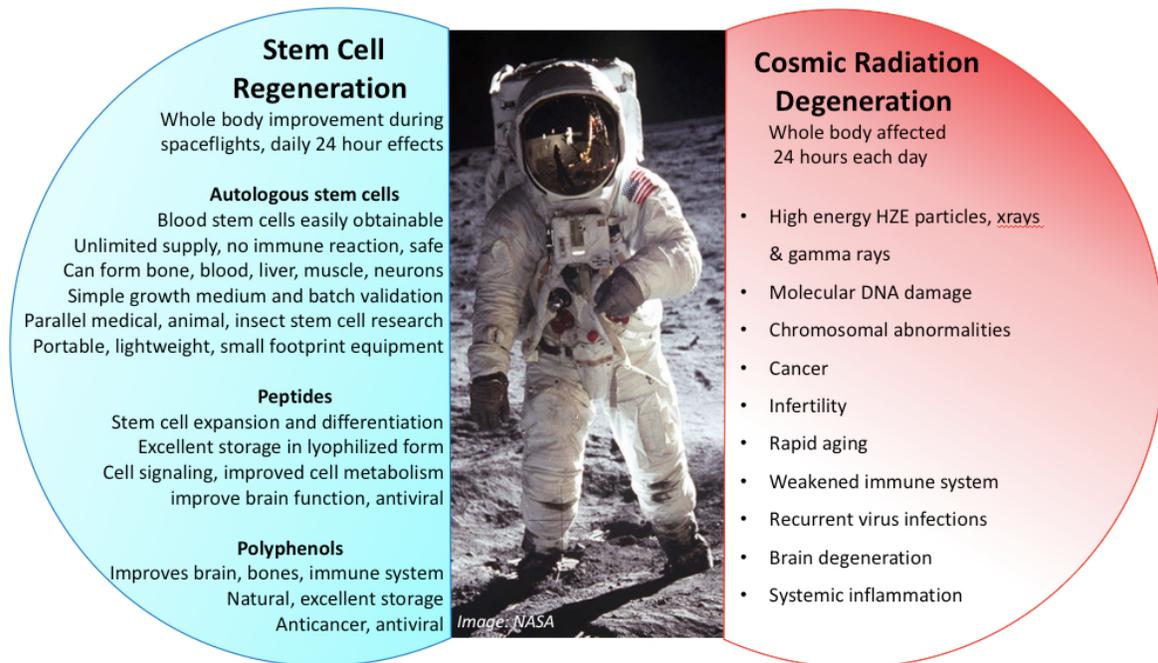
Summary of the possible effects of stem cell regeneration to reverse the damaging effects of cosmic radiation (high-energy particle, gamma rays and x-rays) on the human body. The stem cell hydrogel technique is individualized by using autologous stem cells combined with peptides and polyphenol compounds. The method demonstrates preliminary safety, high efficiency for live stem cell viability and can be used on a daily basis to potentially regenerate damaged tissues.
